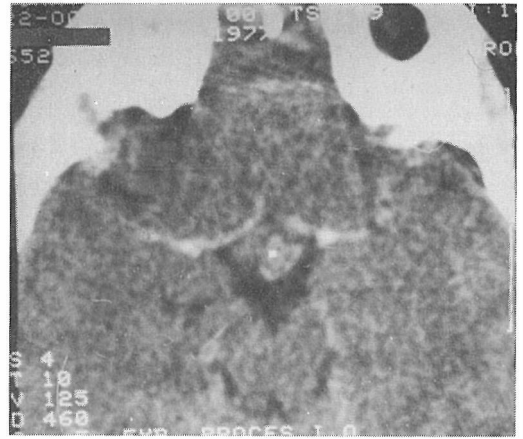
CT scan of Case No. 1; before treatment.
